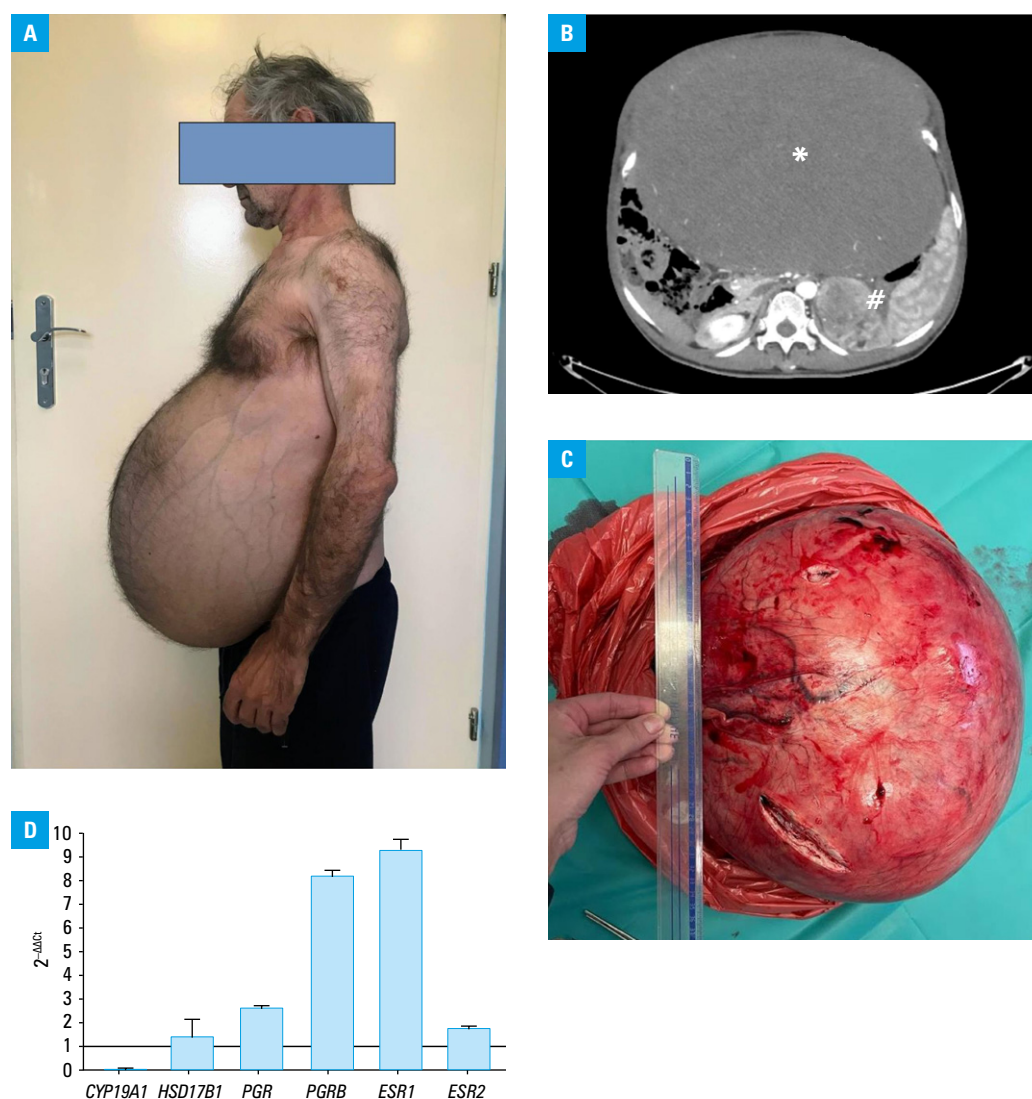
A – a 51-year-old woman with untreated congenital adrenal hyperplasia and a giant abdominal tumor; B – computed tomography scan showing the abdominal tumor (400 mm × 280 mm × 400 mm; asterisk) and the left adrenal tumor (92 mm × 70 mm; octothorpe); C – the resected uterine fibroid (44 cm × 38 cm × 88 cm); D – relative gene expression ($2^{-\Delta\Delta C_t}$ analysis) in the fibroid tissues (value of 1 refers to an equal expression, values > 1 refer to higher expression, and values < 1 refer to lower gene expression on the surface, as compared with the center part of the fibroid tissue); bars and whiskers represent the mean and SD obtained from the averages of 3 replicates of the samples.
